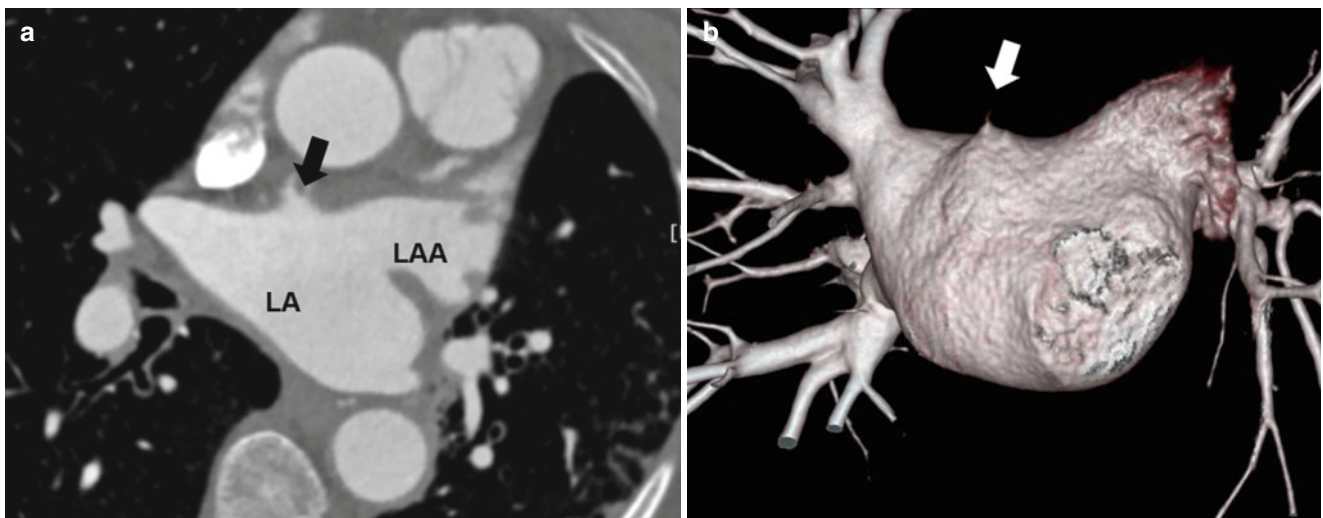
Accessory left atrial appendage. Coronal-reformatted (a) and volume-rendered (b) CT images show a small accessory left atrial appendage (arrow) in the roof of the left atrium. LA left atrium, LAA left atrial appendage
